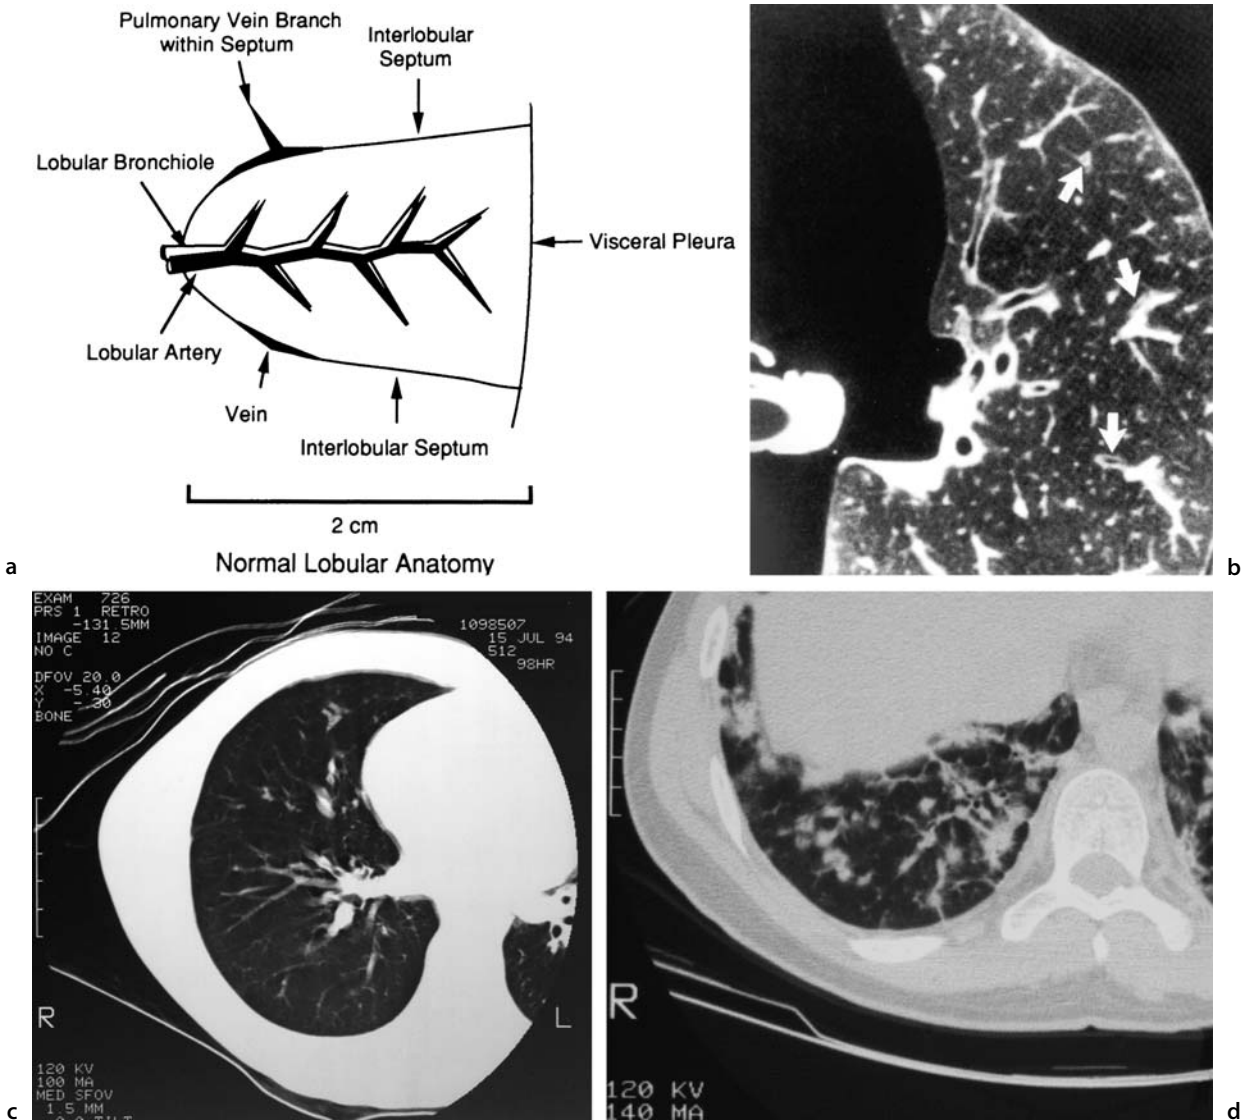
High-resolution CT. This is the anatomy of the secondary pulmonary lobule
